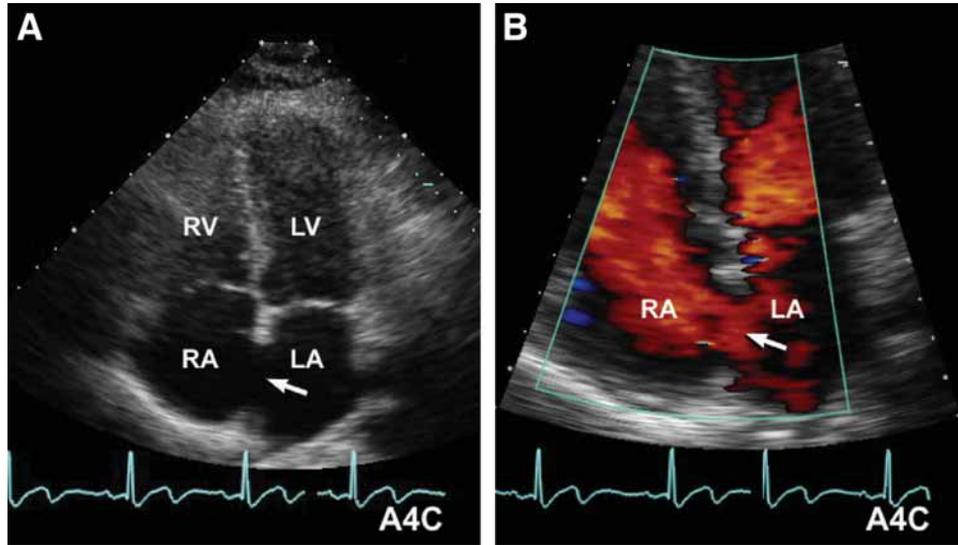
Atrial four-chamber view showing defect or possible drop out in the interatrial septum (arrow, A). Color flow Doppler interrogation showed a typical pattern of predominant left-to-right shunting as seen with secundum atrial septal defects (B). (Please see companion DVD for corresponding video.)
